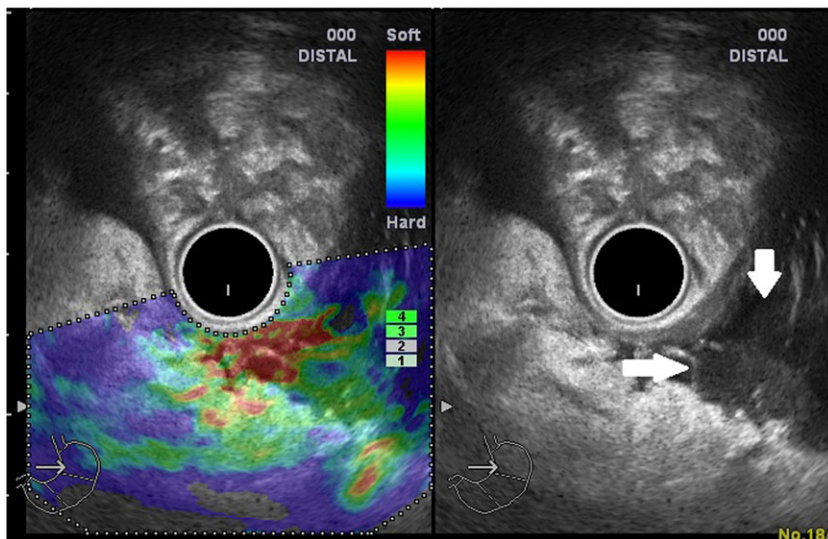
Endoscopic ultrasound elastography in extra-pancreatic necrosis. Extra-pancreatic necrosis is seen as soft region on elastography.
